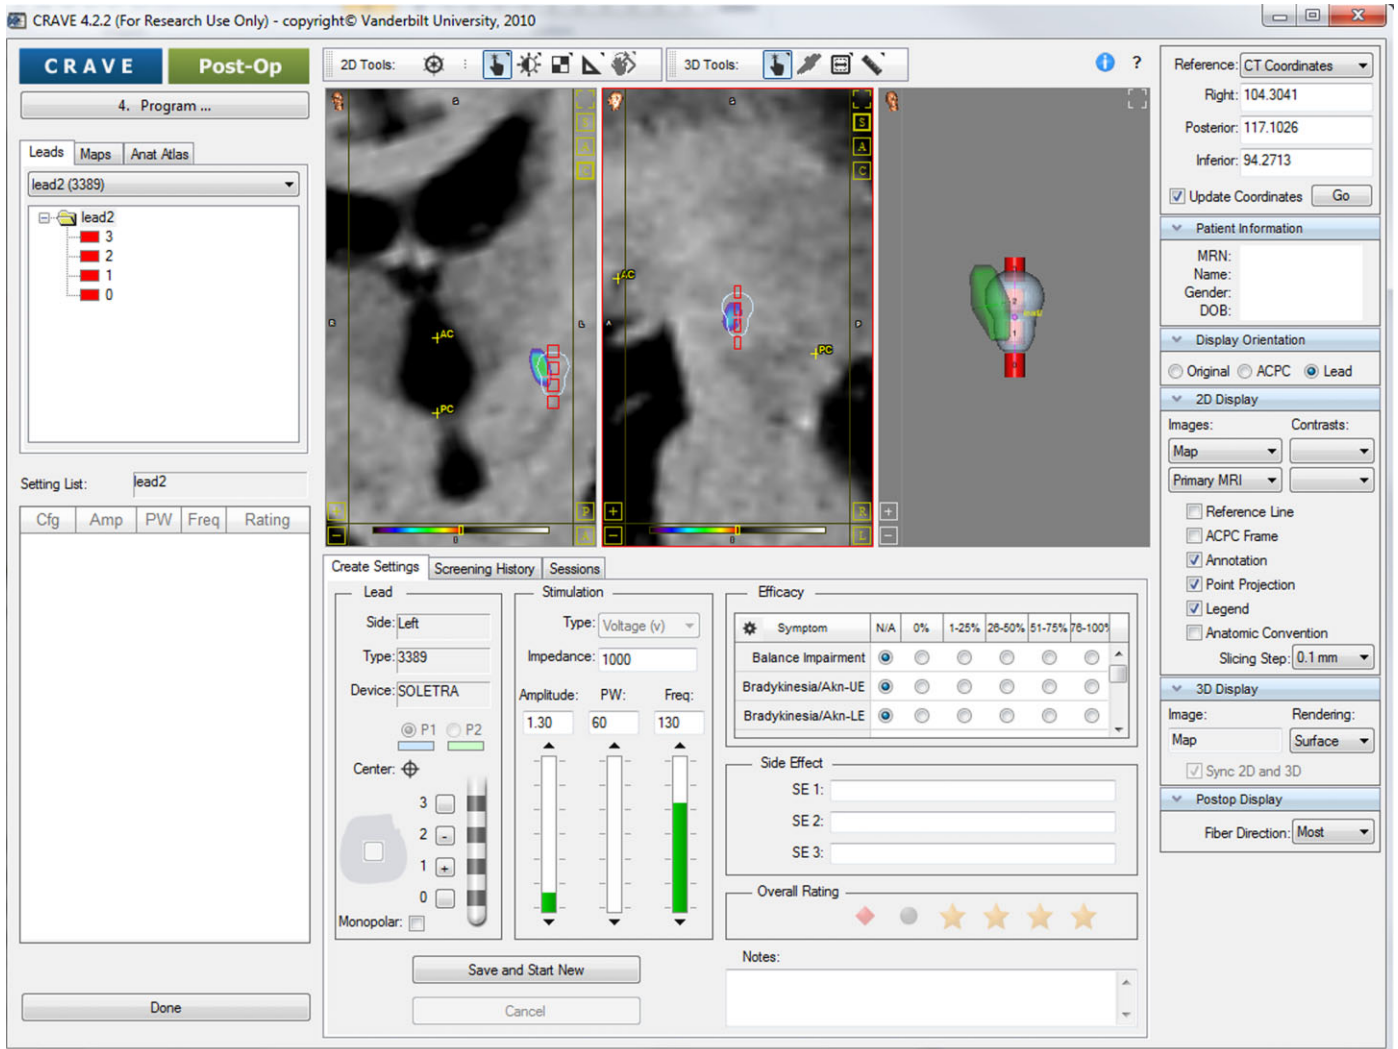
CRAVE software interface that shows how models of volumes of tissue activation can be overlaid on a deep brain stimulation electrode along with the patient’s magnetic resonance imaging and probability maps. The neurologists can visualize models of volumes of tissue activation for various stimulator parameters, with one or more contacts turned on and with monopolar as well as bipolar settings. A 3D rendering is also shown.
